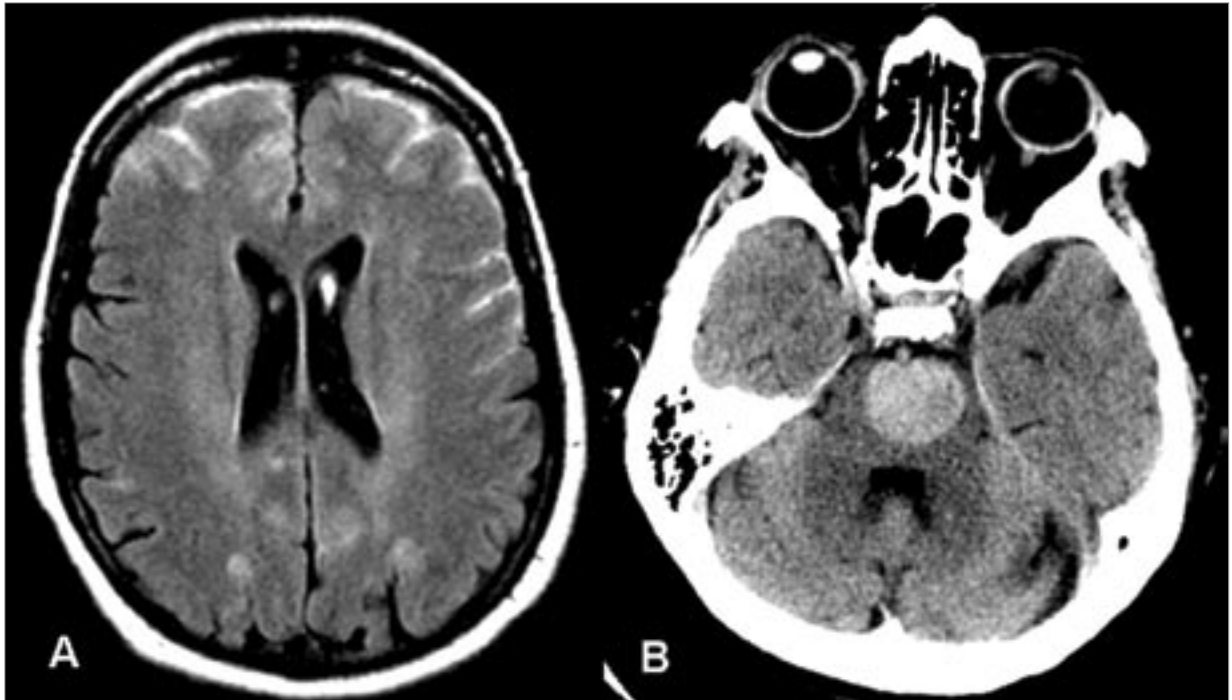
Two patients treated with bevacizumab and low-molecular weight heparin: (A) fluid-attenuated inversion recovery magnetic resonance imagery of subarachnoid hemorrhage in the setting of hypertension; (B) noncontrast computed tomography of pontine hemorrhage without underlying lesion.
